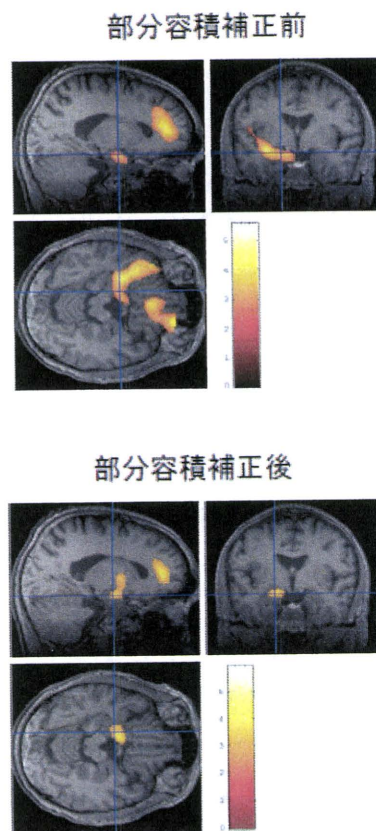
部分容積効果補正による FDG-PET のブドウ糖代謝低下検出部位の変化
